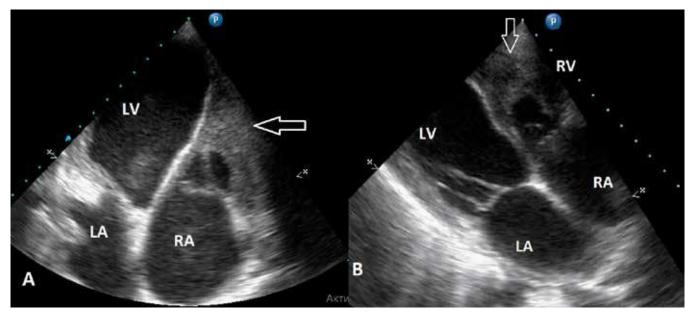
Echocardiographic four-chamber view (Panel A) and parasternal right ventricular inflow view (Panel B) demonstrate echogenic mass (suggestive of a thrombus) in the right ventricle obliterating its cavity (arrows). LV – left ventricle, LA – left atrium
